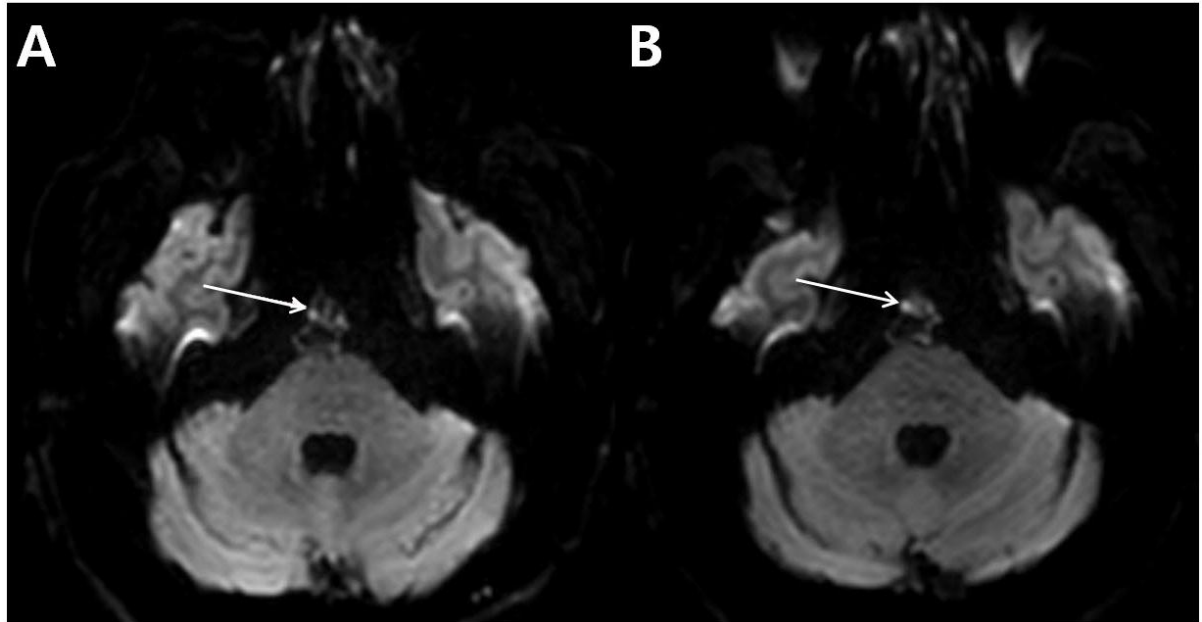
Prepontine epidermoid cyst (white arrow) on DWI before (A) and after (B) UES balloon dilatation and dexamethasone administration.
